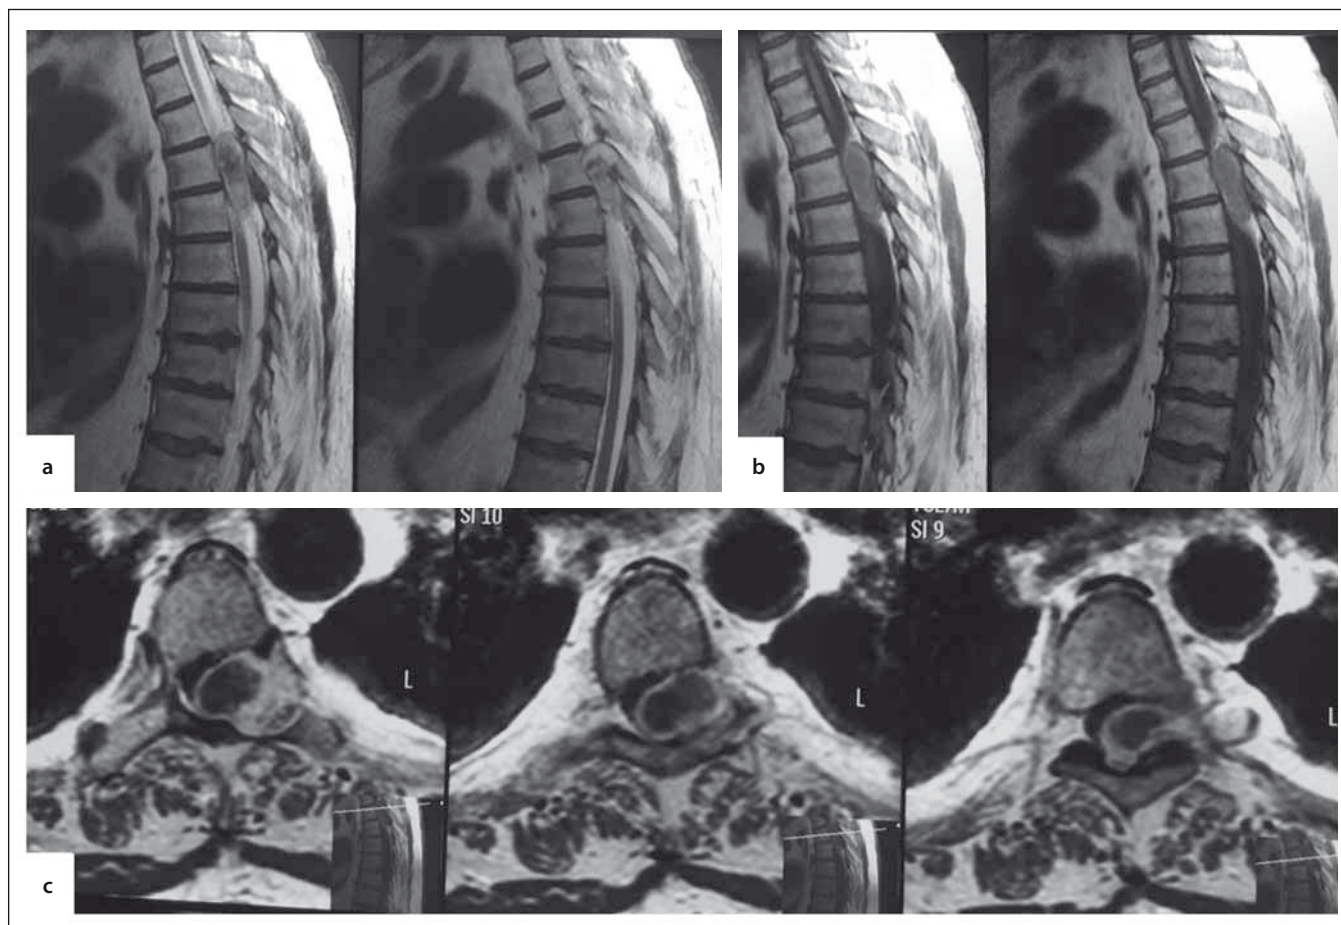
Spinal MRI. A – sagittal T2W, B – sagittal T1W, C – axial T1W. Extramedullary, inhomogeneous, thoracic lesion, occupying the spinal canal, compressing the spinal cord and extending extraforaminally, enlarging the left T5–6 foramen.
